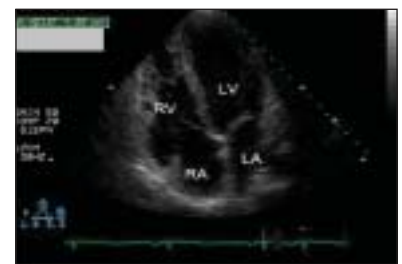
B. Apical 4-chamber RV enlargement.
